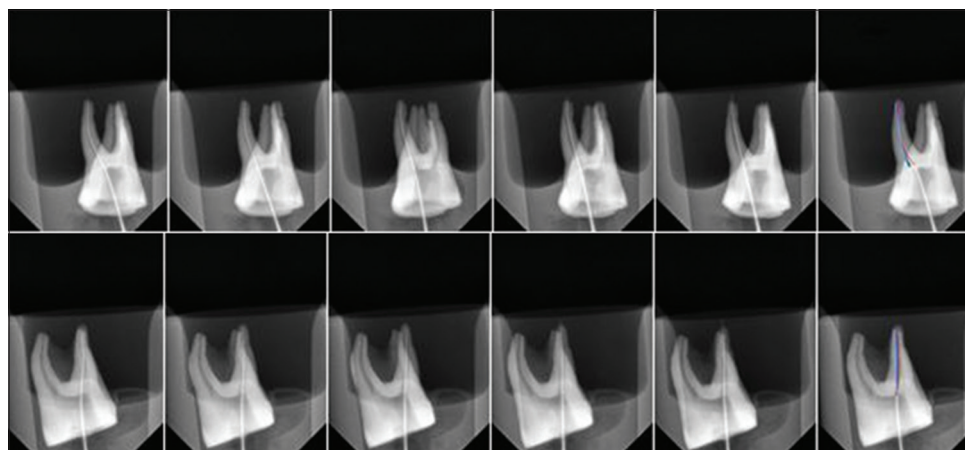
Radiographs of five levels of instrumentation and their superimposition in buccolingual and mesiodistal direction
